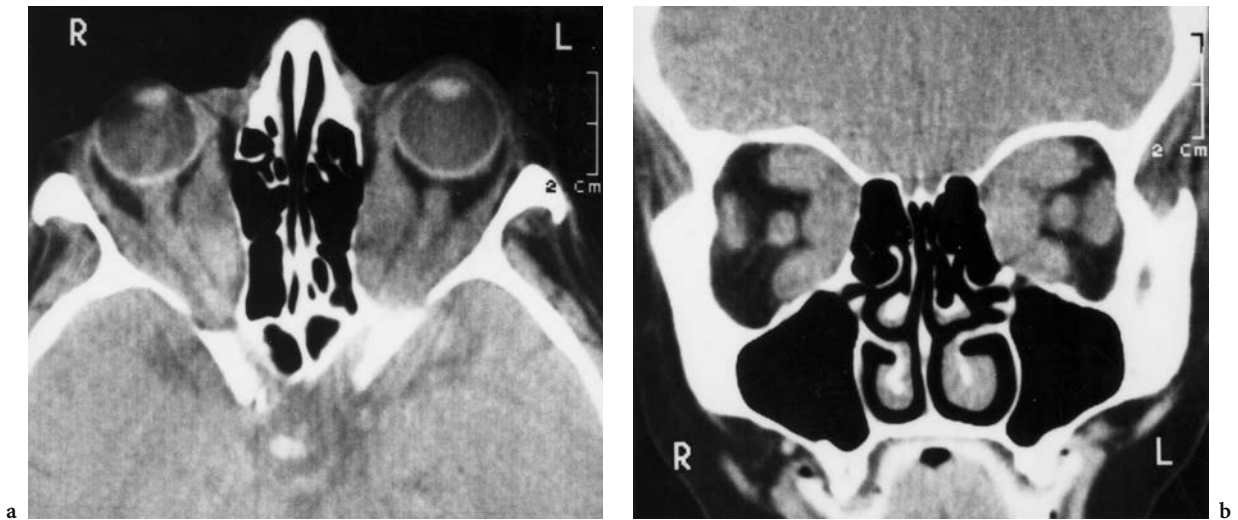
A 73-year-old woman with bilateral exophthalmos. Diagnosis: Graves' disease. CT: a Axial view with severe thickening of all external rectus muscles, excluding the tendinous insertion. Note marked compression of both optic nerves at the apex and pressure exertion on the lamina papyracea responding to slight spontaneous decompression. b Coronal view. (With permission of MÜLLER-FORELL and LIEB 1995b)
